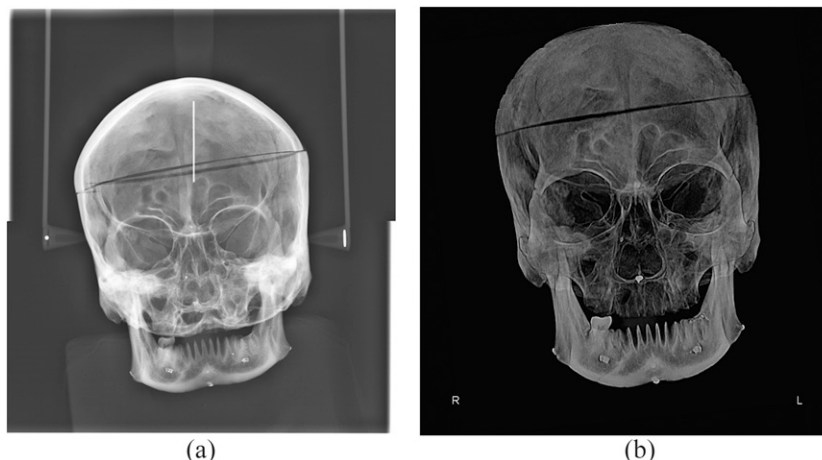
Taking conventional posteroanterior (PA) cephalograms (right) and CBCT PA cephalograms (left) of the skulls tilted towards the right side by 20°.
